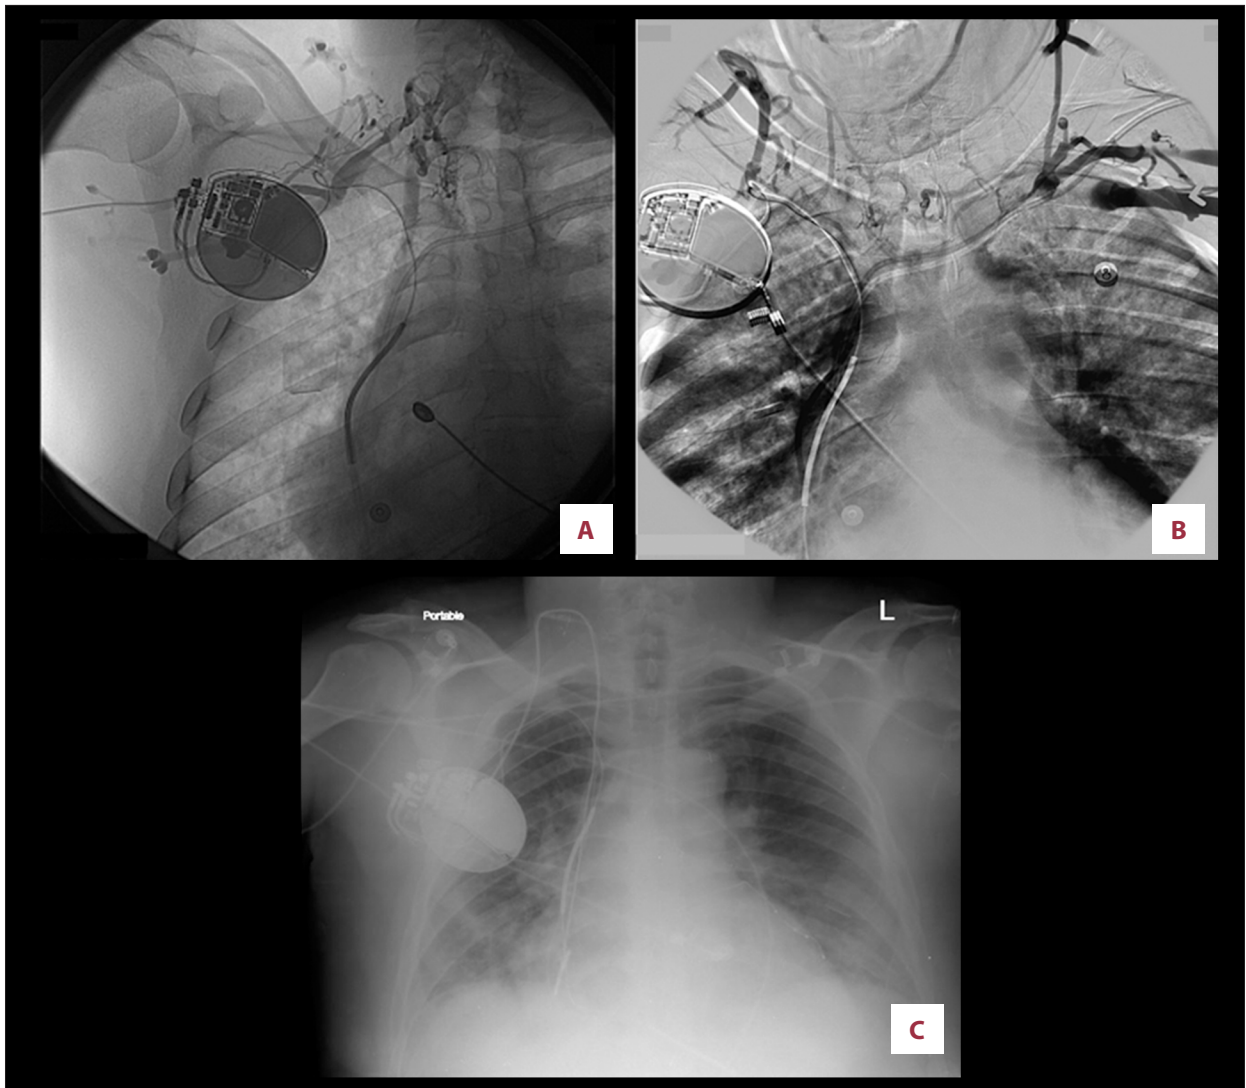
Case 3: (A) Venography of right upper extremity showing severe stenosis of the right and left subclavian veins. Note portacath access port present on the left. (B) Repeat venography revealed total occlusion of the subclavian veins. (C) Chest x-ray posteroanterior (PA) view: biventricular defibrillator placed via right internal jugular vein with right atrial (RA) and coronary sinus (CS) leads.
